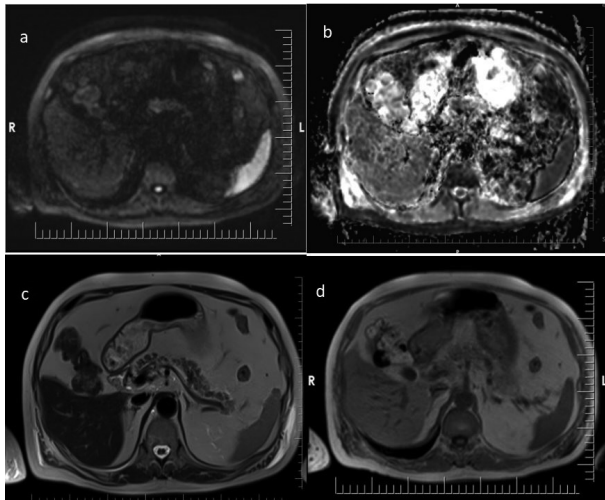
Magnetic resonance imaging (MRI) findings of the pancreas in the overweight patient diagnosed with acute pancreatitis a) An increase of signals showing restricted diffusion in the head and body of the pancreas on diffusion-weighted MR images, b) Signal loss showing restricted diffusion in the head and body of the pancreas head-body on the apparent diffusion coefficient (ADC) map of diffusion-weighted MR imaging, c) Normal-looking pancreatic tissue signal on T2-weighted MRI and d) Normal pancreatic tissue signal on in-phase images.
